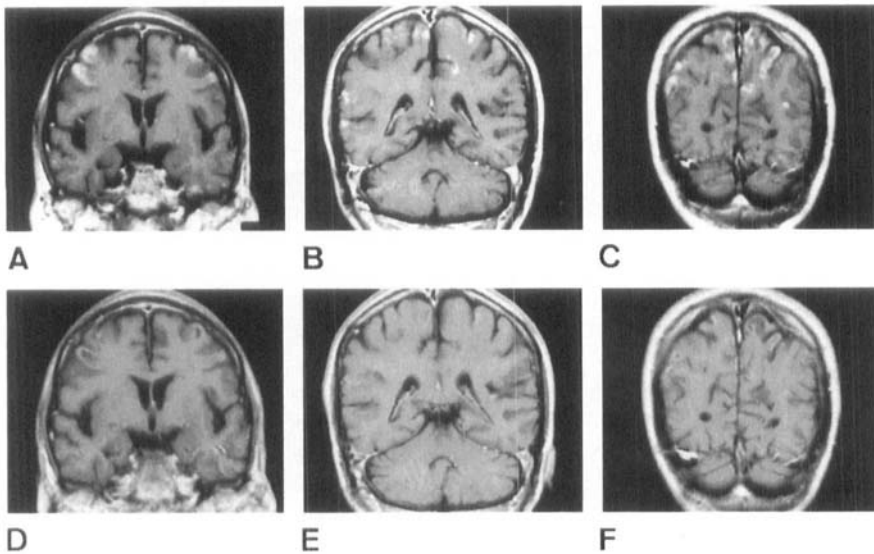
Gadolinium-enhanced brain MRI on the 15th hospital day showing enhancing lesions involving premotor (A), motor (B), and sensory cortices (C). Involvement of the premotor and motor cortex is more severe on the right side. The white matter is relatively spared. On follow-up MRI on the 43rd hospital day, the enhancement appears almost resolved (D-F).
